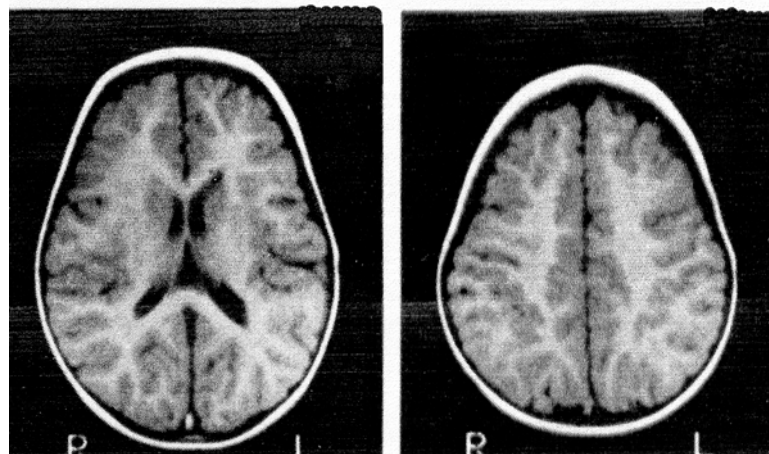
MRI scans after 90 days of treatment.
